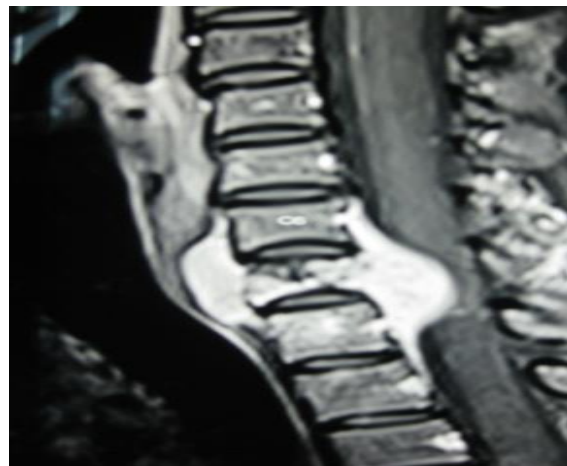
T2 weighted MRI scan of the cervical spine showing collapsed C7 vertebra with soft tissue component compressing the spinal cord.
